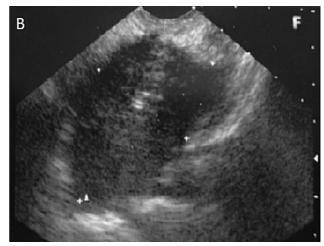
A. Computed tomography of the abdomen revealed a 5x4 cm mass arising from the gastric body. B. Endosonography showed a heterogeneous echoic lesion indistinguishable from the layers of the gastric wall, measuring about 51x31 mm.
